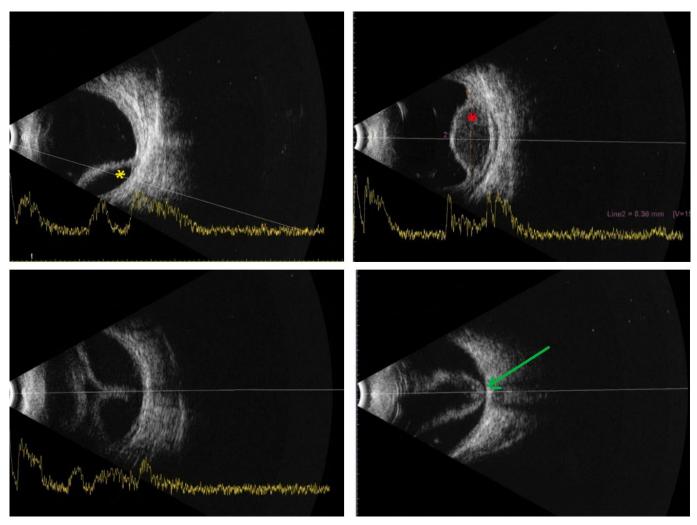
B scan ultrasonography images showing (a) Serous choroidal detachment, with characteristic dome shape and hypoechoic space within the dome (yellow asterisk) (b) Hemorrhagic choroidal detachment with heterogenic areas and hyperechoic space within due to blood (red asterisk) (c) Kissing choroidal detachments apposing each other (d) Retinal detachment, with characteristic attachments at disc(green arrow) and ora serrata.
